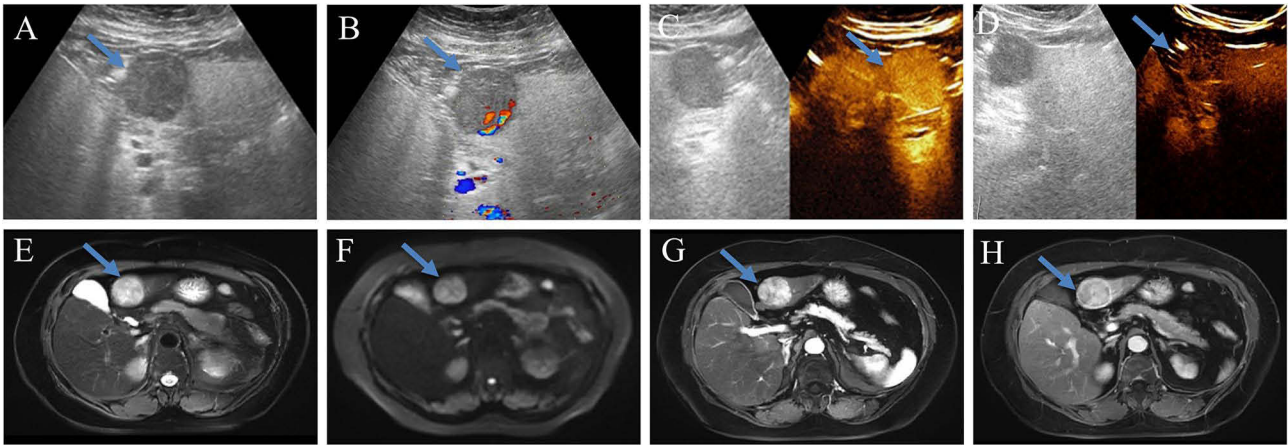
A 77-year-old woman with NDPHCC in the left outer lobe, and the mass was indicated by the blue arrow. (A) Grayscale ultrasound showed a hypoechoic, homogeneous and regular tumor. (B) Color Doppler imaging showed a grade III blood flow. (C) The arterial phase of CEUS showed uniform and significant enhancement. (D) The delayed phase showed low enhancement. (E) T2-weighted image showed a mass with higher signal. (F) Diffusion-weighted image (b = 500) showed a high signal mass. (G) The CEMRI showed significantly enhancement in arterial phase. (H) The delayed phase showed low enhancement and enhancing capsule.
